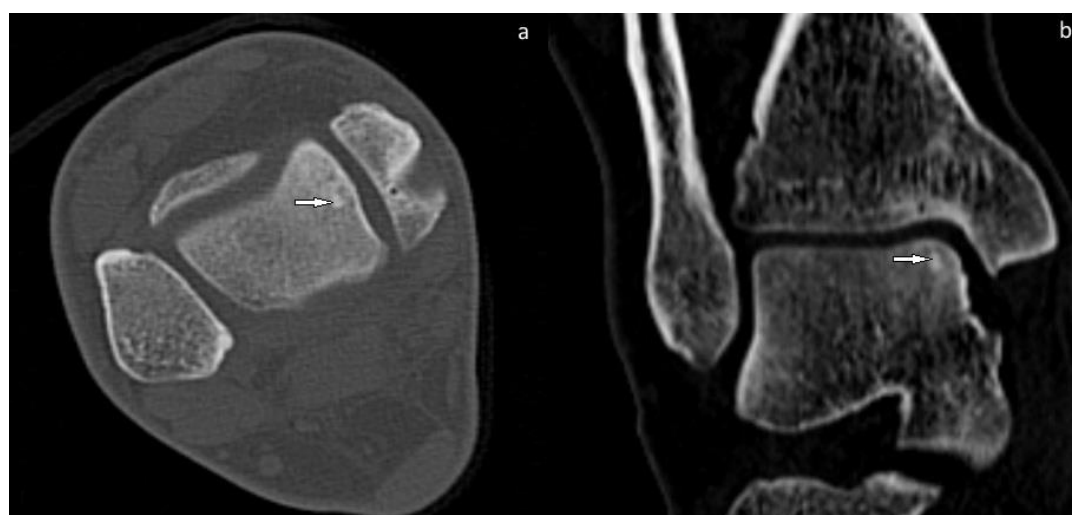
A 34-year-old male patient with ankle pain. Thin-slice, non-contrast (a) (axial), (b) (coronal) reformatted CT images do not show significant sclerosis in the talus medial, but a hypodense nidus with a partially calcified center is visible in the talus (white arrow). No significant irregularities were detected on lesion localization and other joint surfaces. CT—Computerized Tomography.
